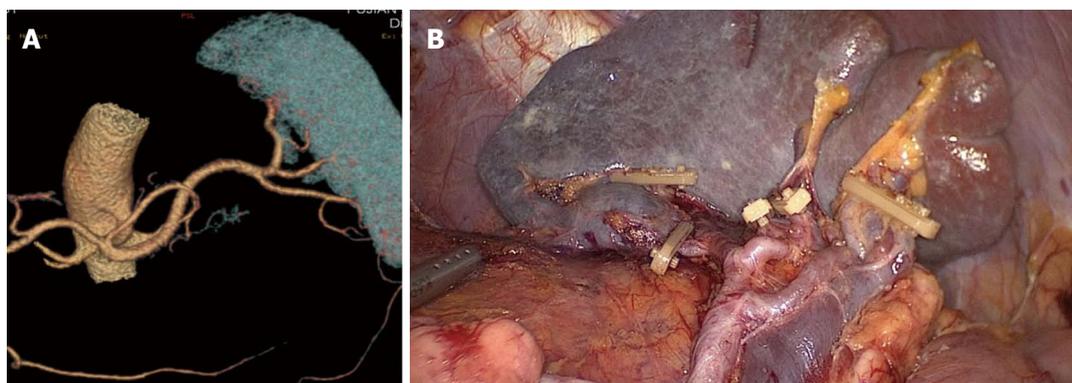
Three-lobe splenic vessels. A: Preoperative assessment of the splenic vascular anatomy using computed tomography with 3D imaging images; B: Operative view after the completion of splenic lymph node dissection.
